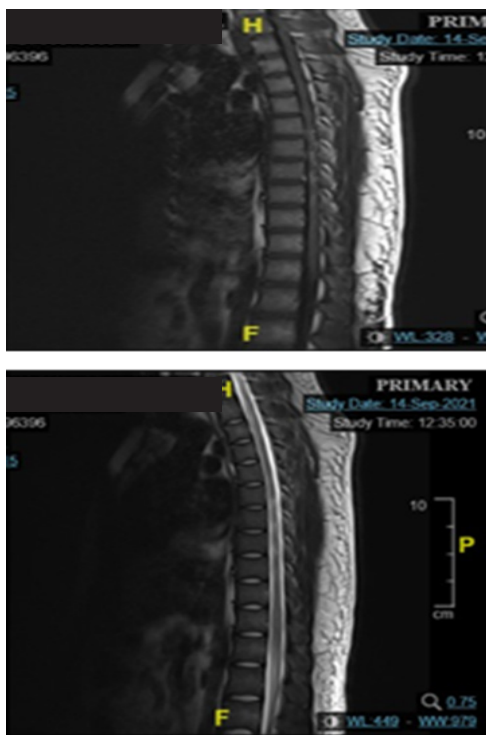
Magnetic Resonance Imaging. There was hyperintensity at the 5th until 9th (arrow) thoracic level suggestion a demyelinating lesion supporting transverse myelitis.
